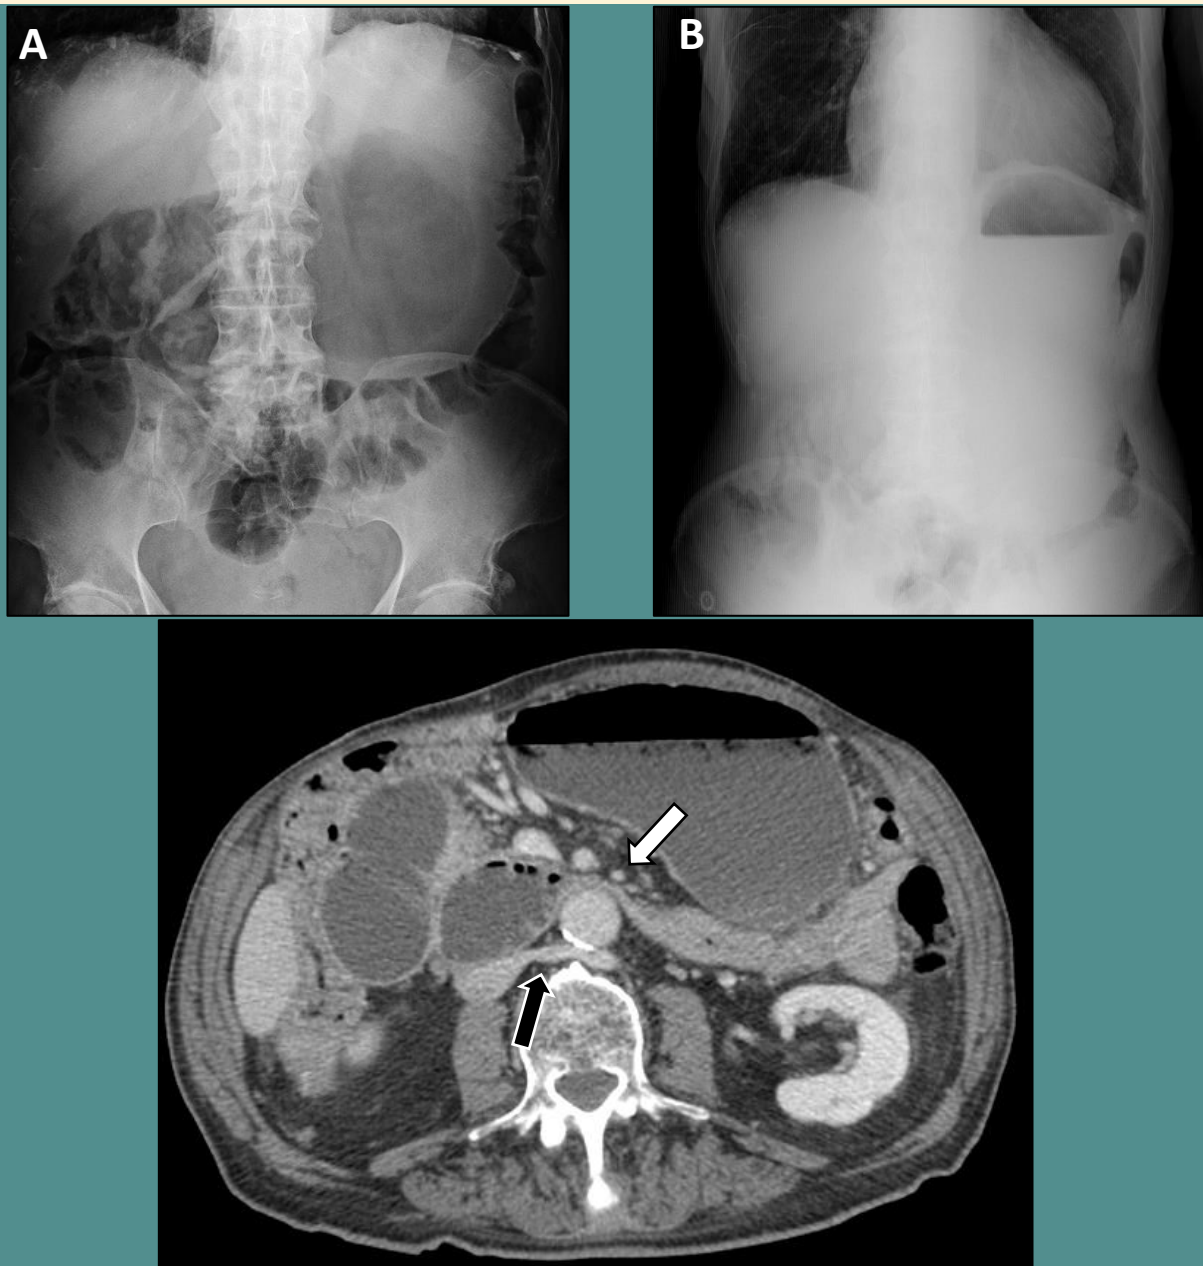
Abdominal X ray in supine (A) and erect (B) position showing a marked gastric chamber dilation. Contrast enhanced abdominal CT-scan (C). There's a reduction in the distance between the SMA and the abdominal aorta with a reduced angle that results in compression of the third portion of the duodenum with proximal dilation (white arrowhead). There's also a retro-aortic left renal vein (black arrow).
